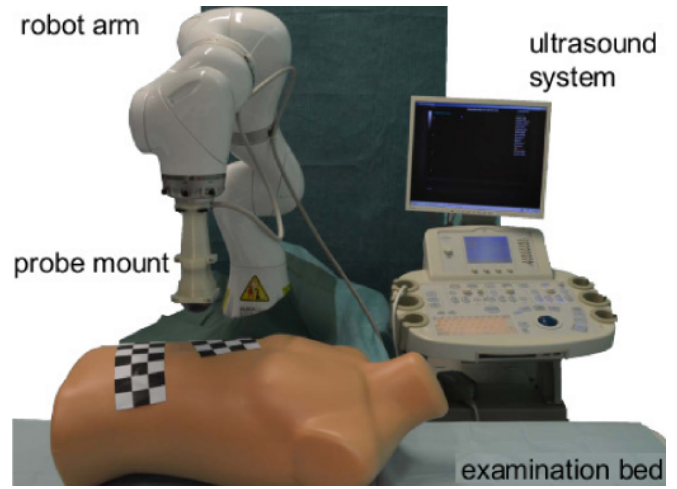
Configuration of the MRI-based ultrasound navigation system [16].
